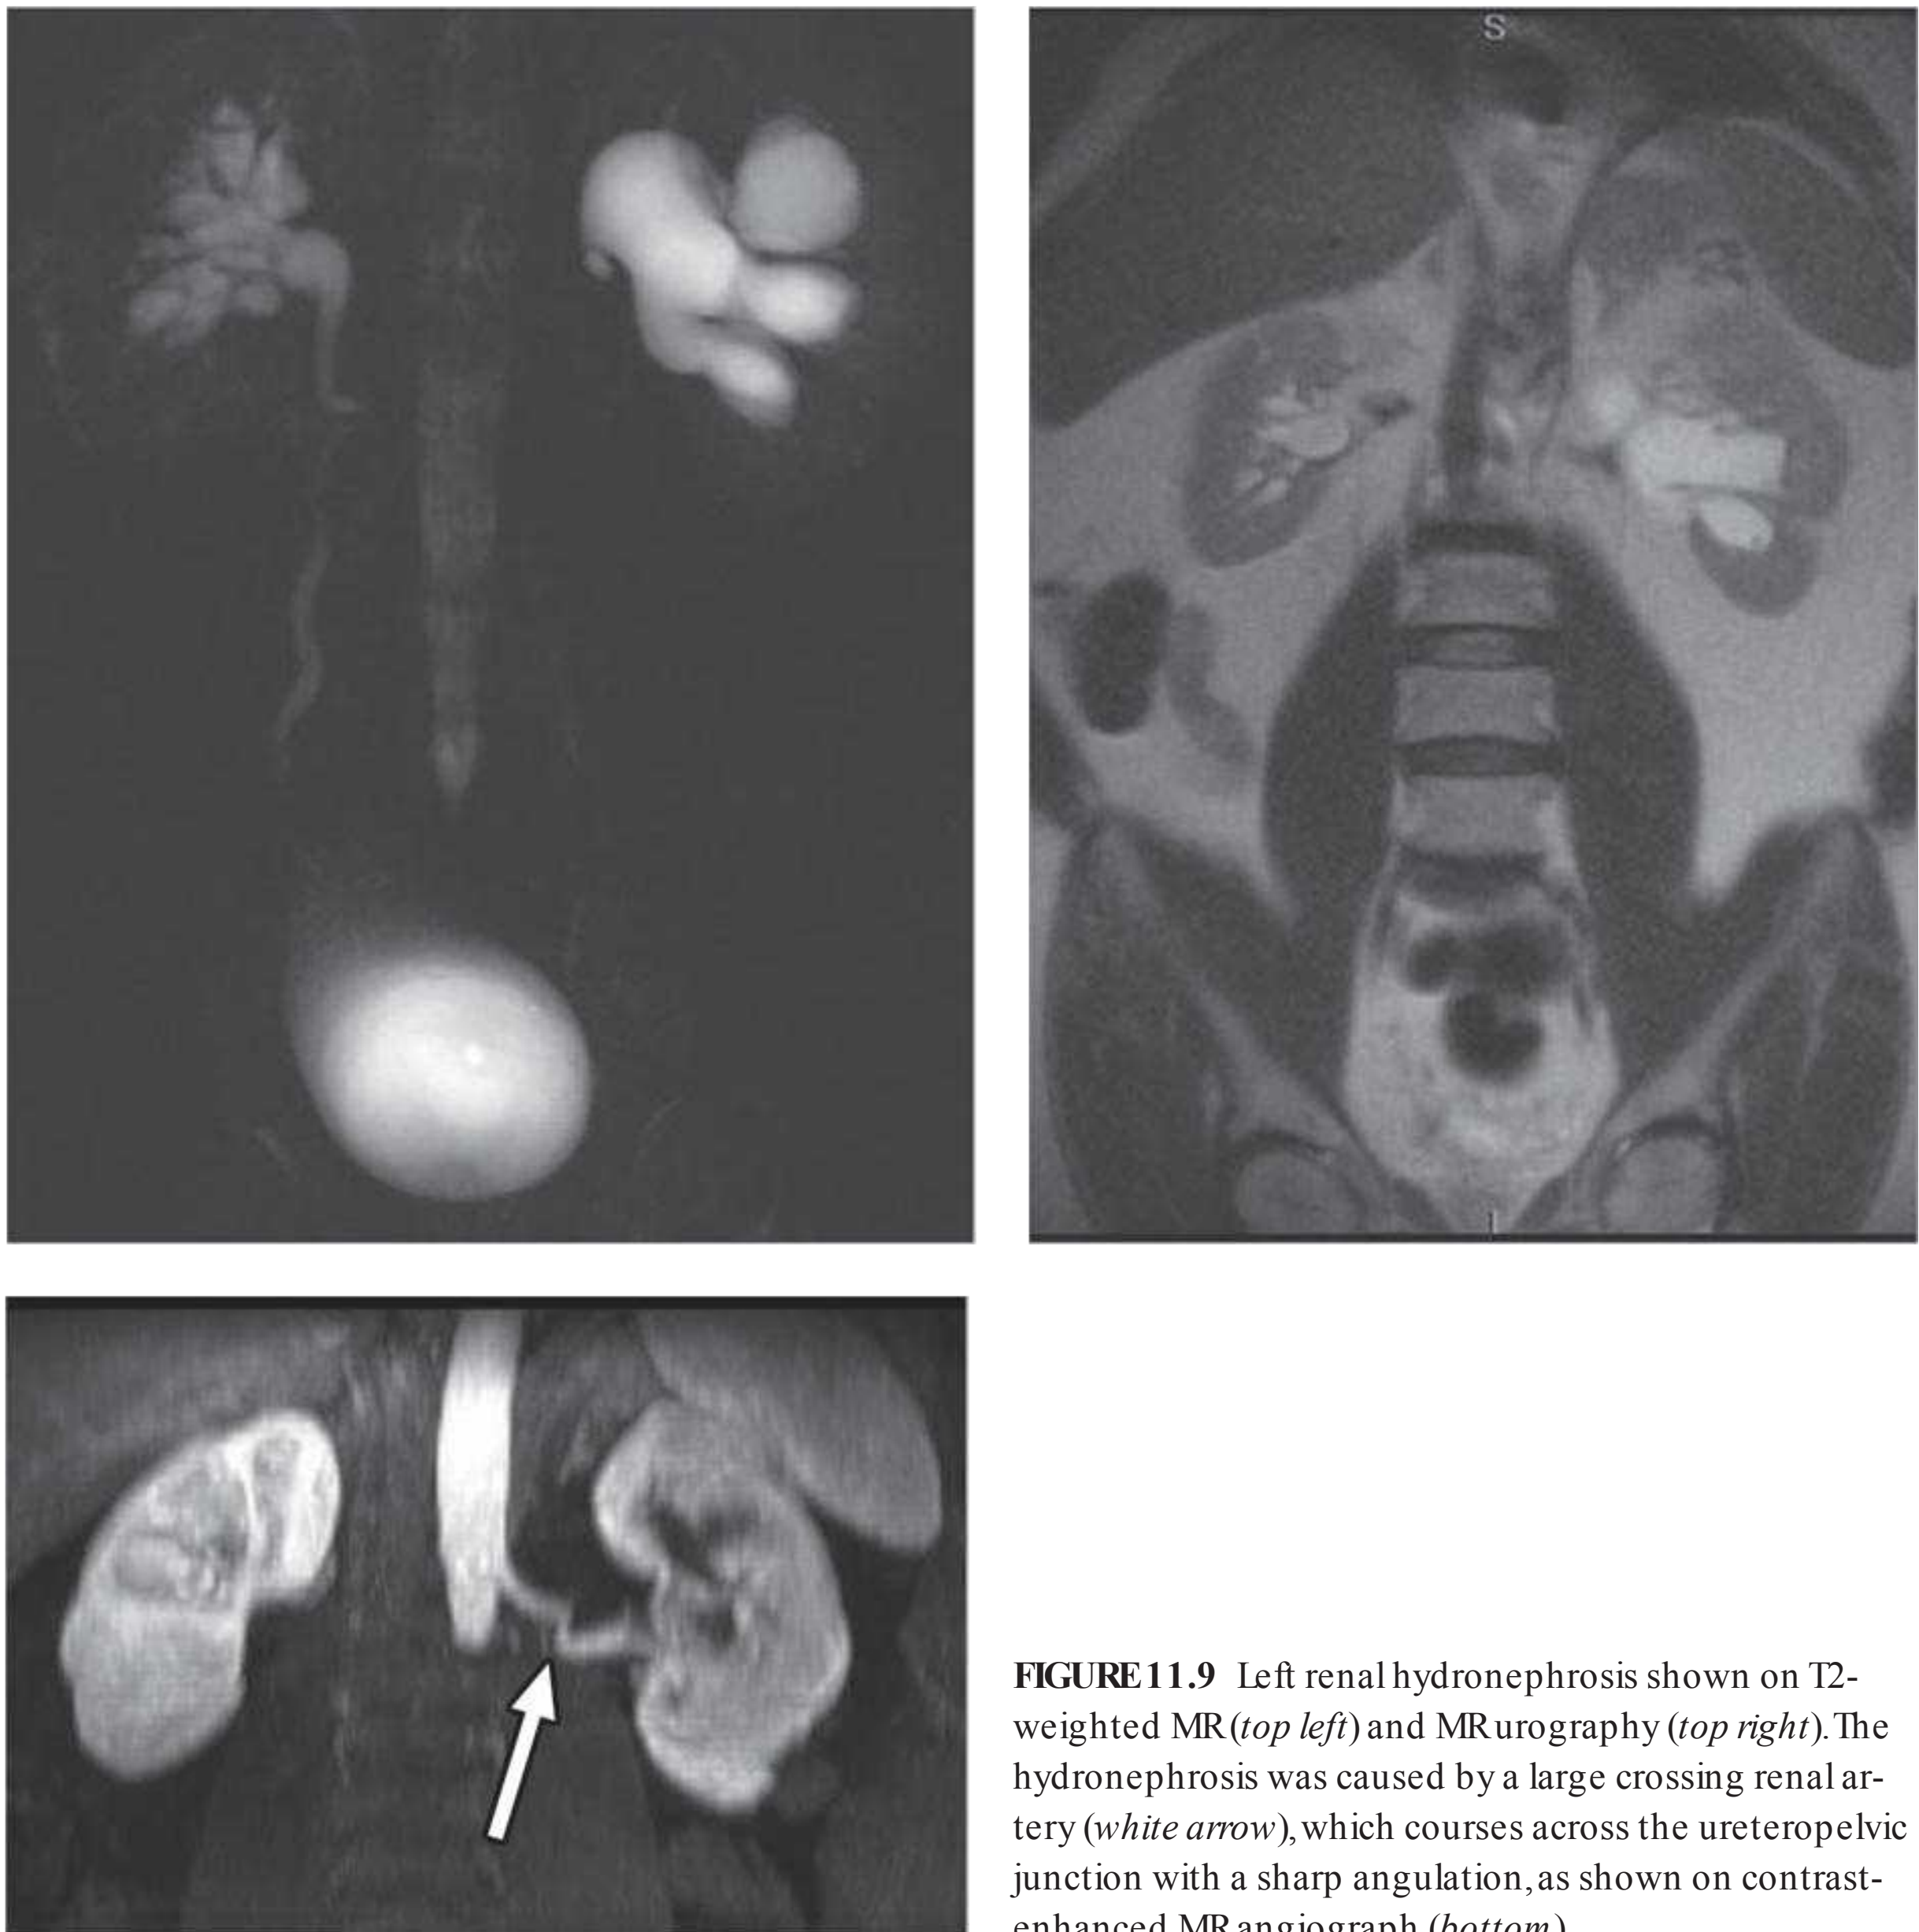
Left renal hydronephrosis shown on T2-weighted MR (*top left*) and MR urography (*top right*). The hydronephrosis was caused by a large crossing renal artery (*white arrow*), which courses across the ureteropelvic junction with a sharp angulation, as shown on contrast-enhanced MR angiograph (*bottom*).
